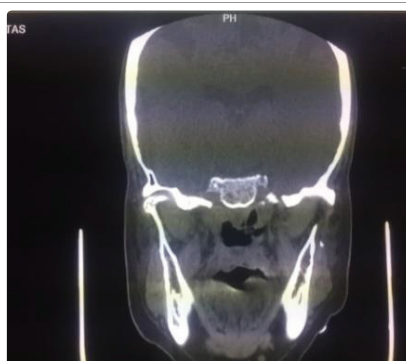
Coronal CT image.
